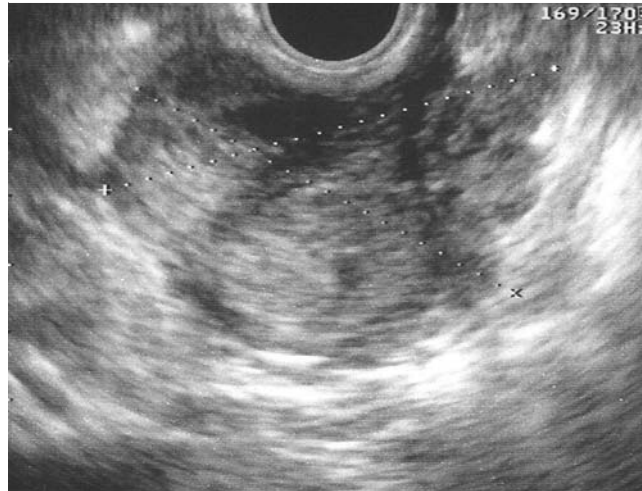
Endoscopic ultrasound (EUS) view showing a homogeneous hypoechoic mass arising from the muscularis propria without evidence of deep involvement.
